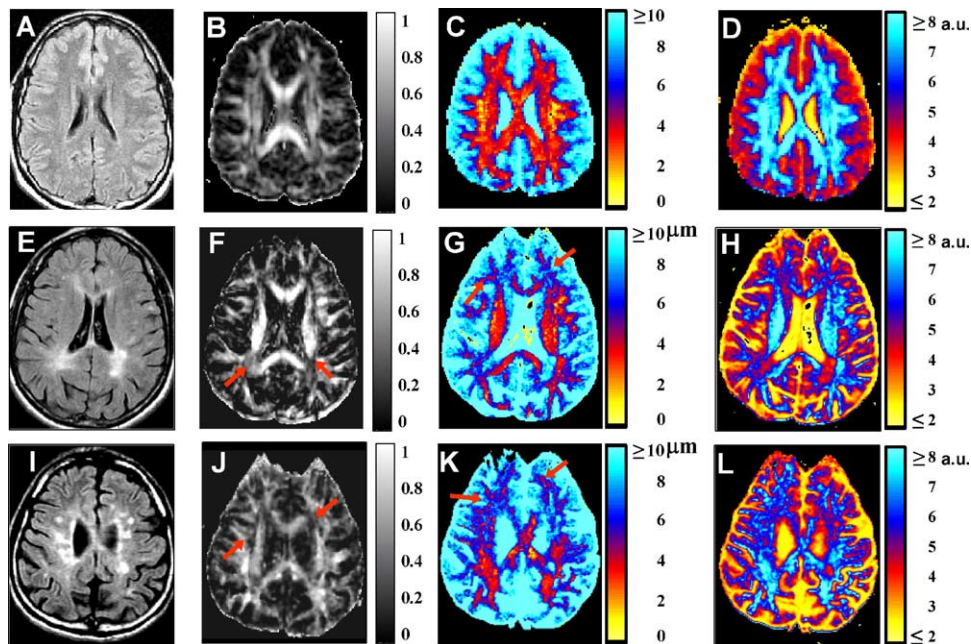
MRI data of a healthy subject and two MS patients including FLAIR (left column), FA (second column), q-space displacement images (third column) and q-space probability images (fourth column). The healthy subject (images A–D) had no history of neurological disorders. The first MS patient (images E–H) had extended disability severity score (EDSS) of 3.5 (Patient 7 in Table 1) while the second patient (images I–L) had an EDSS of 6.0 (Patient 2 in Table 1). Arrows indicate areas of abnormal image intensity in MS lesions (FA images F and J) and in NAWM (displacement imaging G and K).
